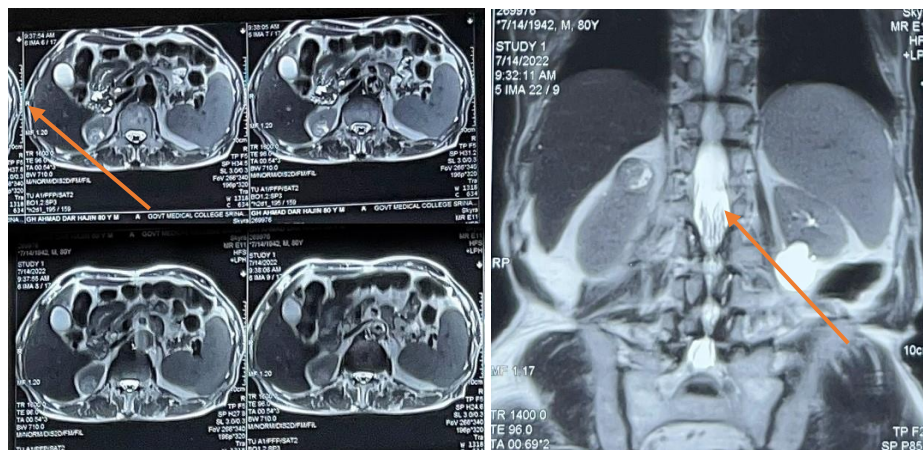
Axial and Coronal sections on MRI Abdomen showing Right Renal mass (orange arrow)
